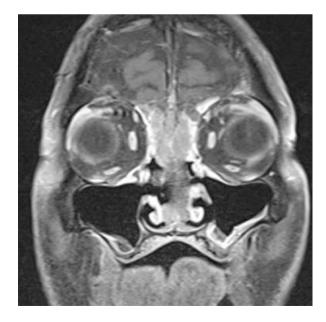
MRI brain T2 FLAIR with contrast showing extensive involvement of the nasal soft tissues
